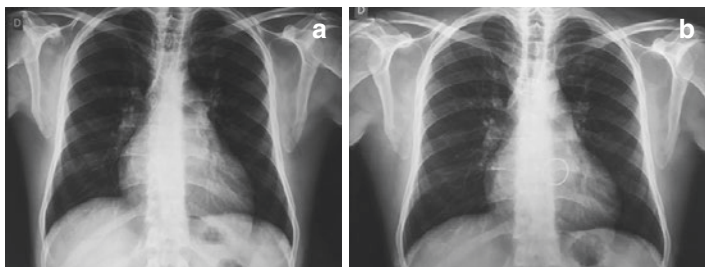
(a) Preoperatively chest X-ray exam evidencing cardiomegaly and pulmonary artery dilation. (b) Postoperative chest X-ray exam evidencing the presence of mechanic mitral valve prosthesis and reducing of pulmonary artery dilation
